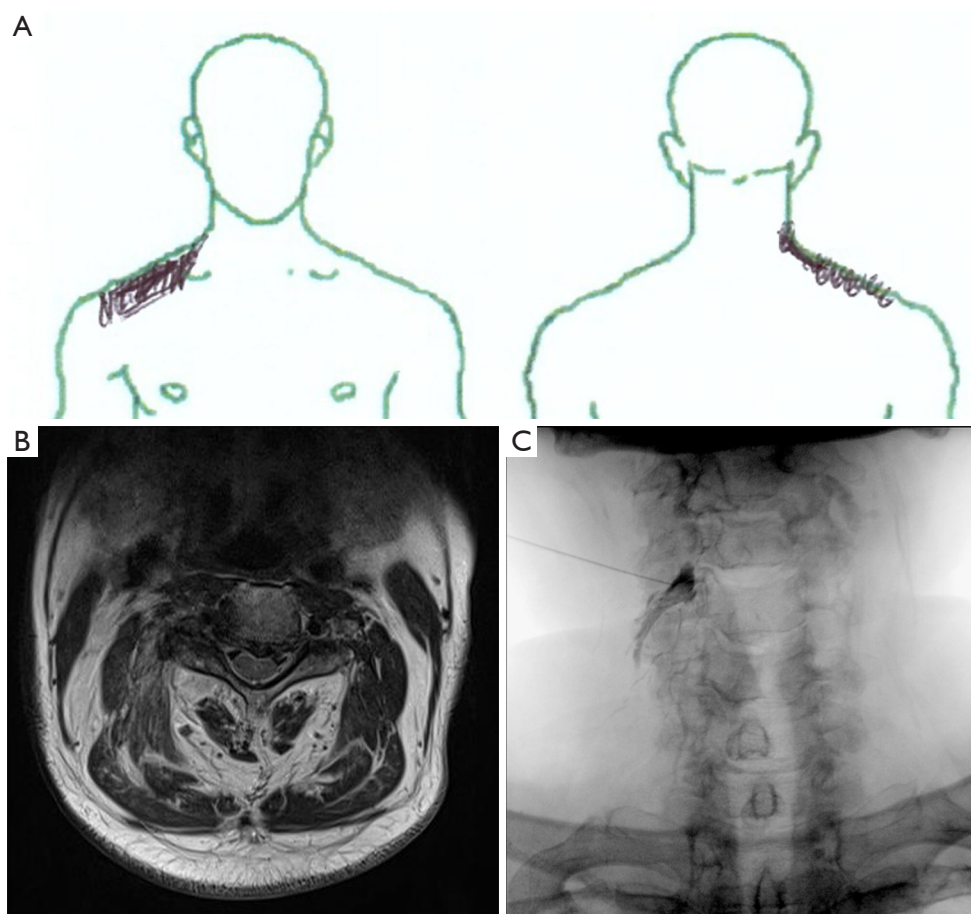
Pain distribution and imaging findings. (A) The area of pain was drawn by the patient before the treatment. (B) Axial T2-weighted cervical magnetic resonance imaging revealed foraminal stenosis at the right C3–4 level. (C) Fluoroscopy-guided selective right C4 nerve root injection was performed.
